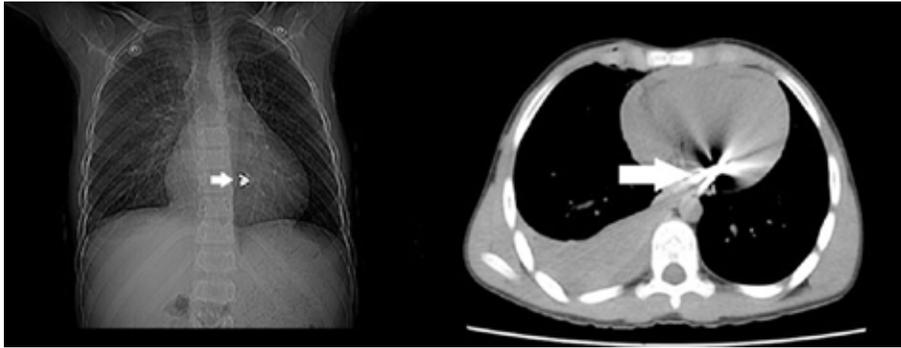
Chest radiograph with radiopacity (pellet) in the mediastinum. Computed tomography indicated the location of the radiopacity (pellet) in the left atrium.
